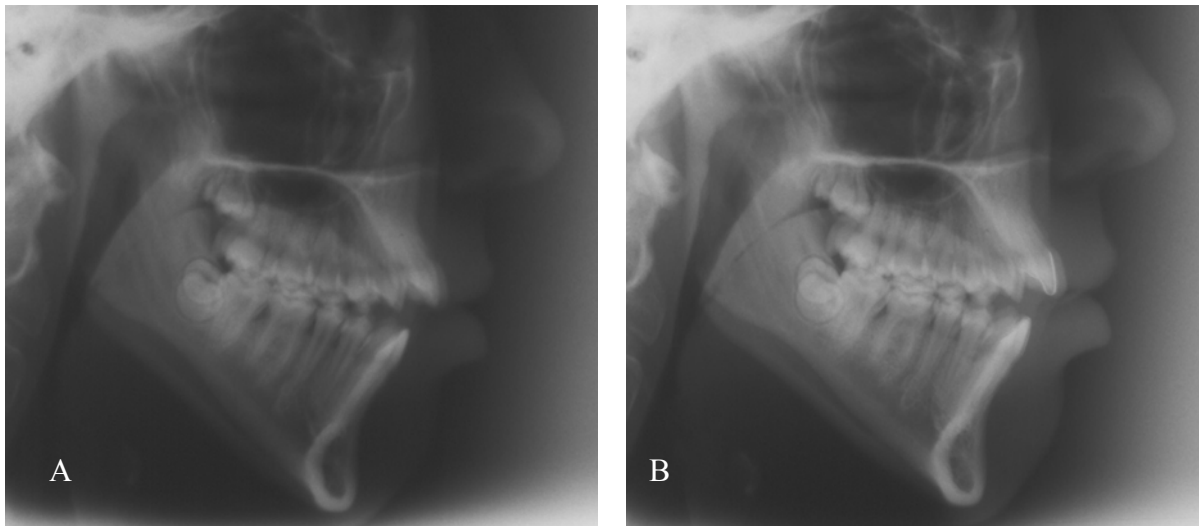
A. Lateral cephalometric radiograph without any lead markers. The double image in the ramus/corpus and posterior teeth was ascribed to improper positioning in the cephalostat and another radiograph requested. B. Lead markers were placed on the teeth before taking the second radiograph.
